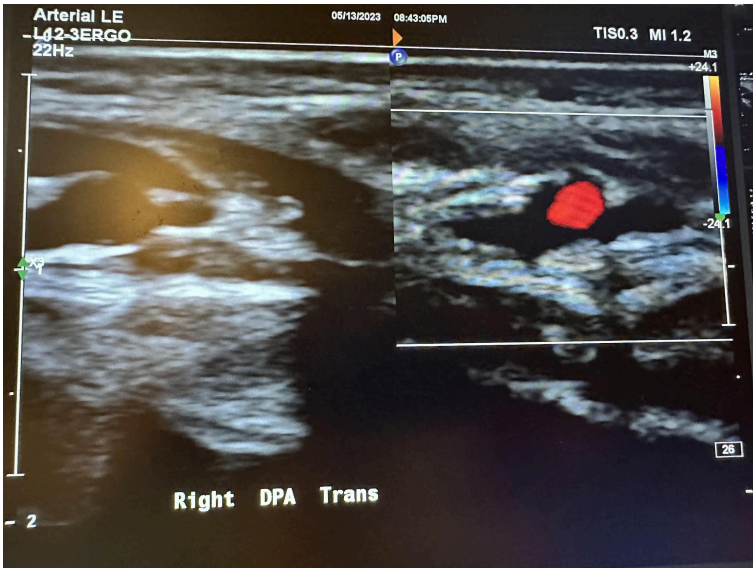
Side-by-side transverse images of the right dorsalis pedis artery without color Doppler and with color Doppler.
